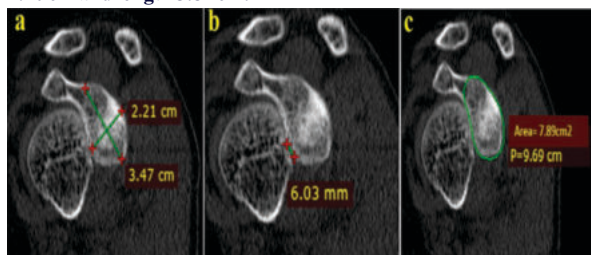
19-year-old male with single episode of anterior shoulder dislocation on right side. a) Oblique sagittal CT scan showing glenoid width 2.21 cm and length 3.47 cm on dislocated side; b) Mild flattening of anterior glenoid curvature by 6.03 mm seen; c) Cross-sectional area on dislocated side measures 7.89cm².
